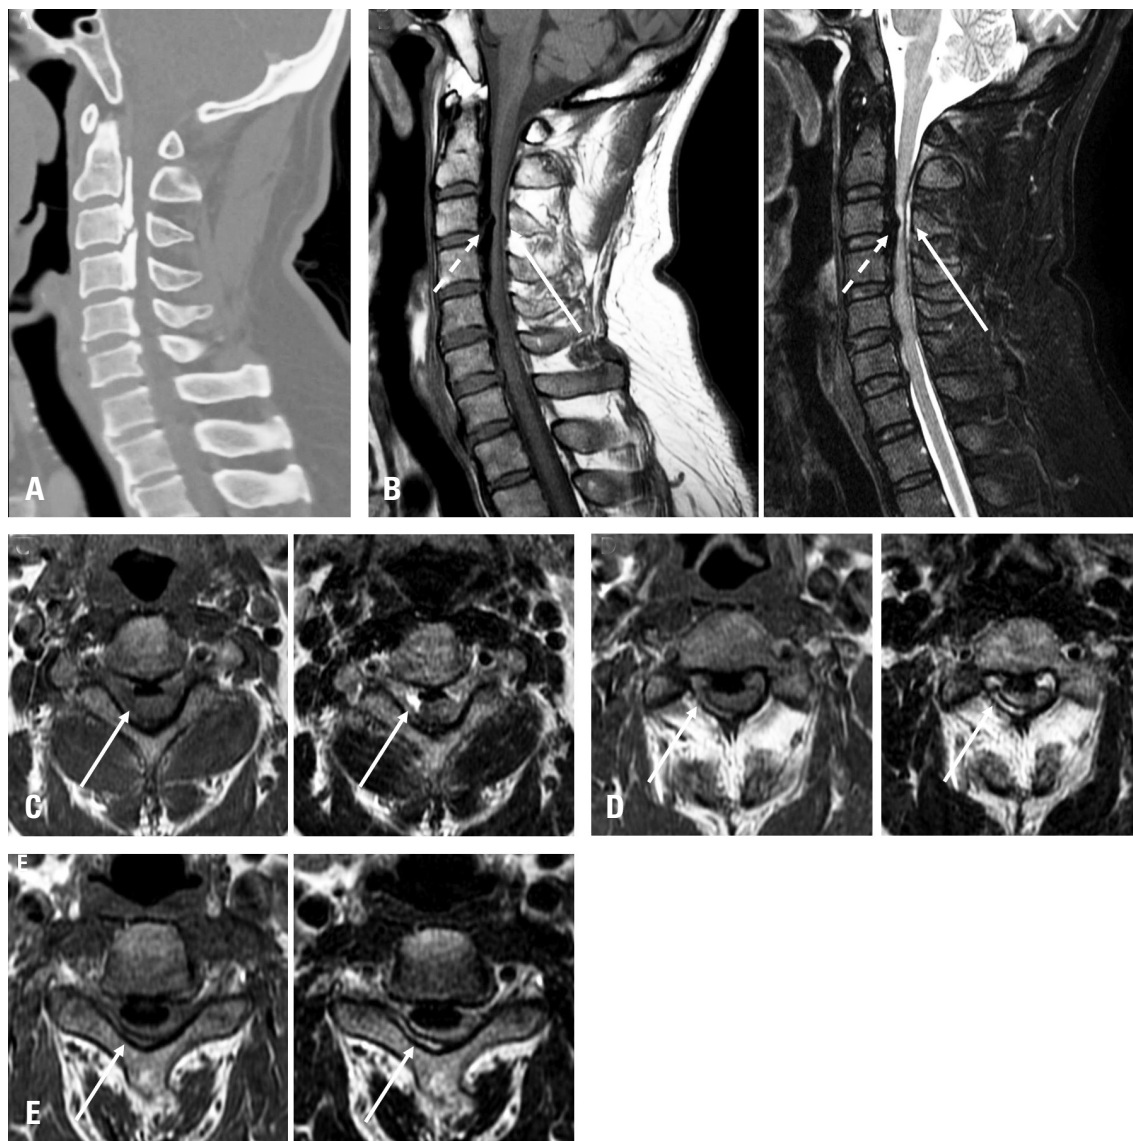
(A) Preoperative computed tomography (CT): sagittal view. (B) Preoperative magnetic resonance imaging (MRI): T1-weighted image (left), T2-weighted image (right). Sagittal view, showing (pre-existing ossification of the posterior longitudinal ligament (white dotted arrow) and a cervical epidural hematoma (white arrow). (C, D, E) Preoperative MRI: T1 weighted image (left) and T2-weighted image (right). Axial views at the C2-3, C3, and C3-4 level, respectively. (A) On a sagittal view of computed tomography of the cervical spine, pre-existing ossification of the posterior longitudinal ligament is abutting the cord anteriorly from C2 to C6. (B) Posterior to the cord, there is an isointense/hyperintense signal lesion on T1/T2-weighted imaging, suggesting acute epidural hematoma compressing the cord. Cord signal change is also observed on T2-weighted imaging at the C3-4 level (C, D, E) On an axial view, the cervical cord is compressed by cervical epidural hematoma predominantly on the right posterior side at the C2-3, C3, and C3-4 levels, respectively.
